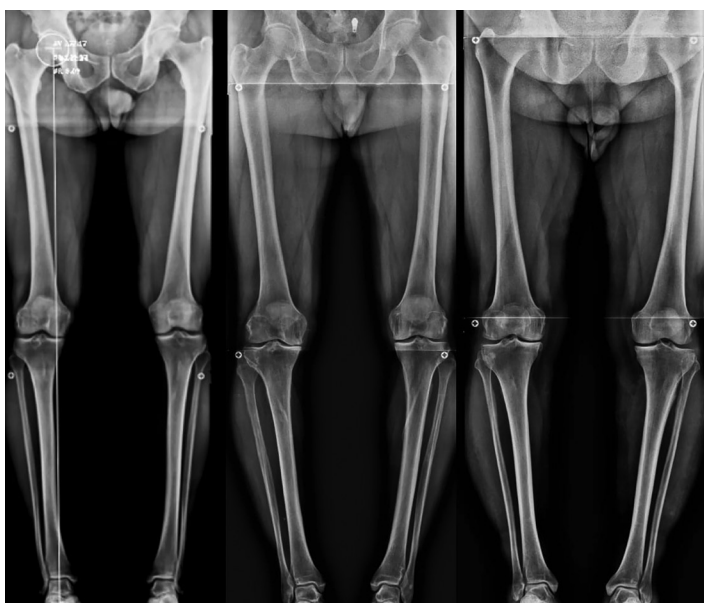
Preoperative long-leg alignment and sample X-rays
